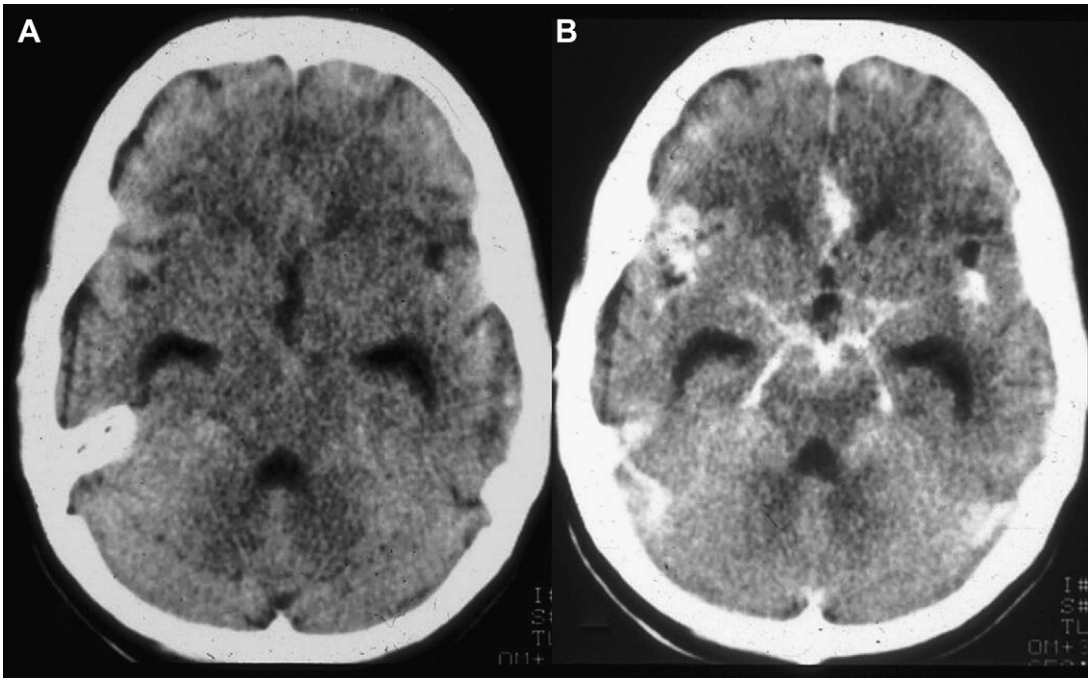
Tubercular meningitis in a 45-year-old man who presented with seizures and fever. Axial plain CT image (A) shows dilated bilateral lateral ventricles with diffusely swollen gyri and obliteration of basal cisterns. Axial postcontrast CT (B) shows thick meningeal enhancement in basal cistern regions. (From Shah GV. Central nervous system tuberculosis: imaging manifestations. *Neuroimaging Clin N Am* 2000;10(2):355–74; with permission.)
